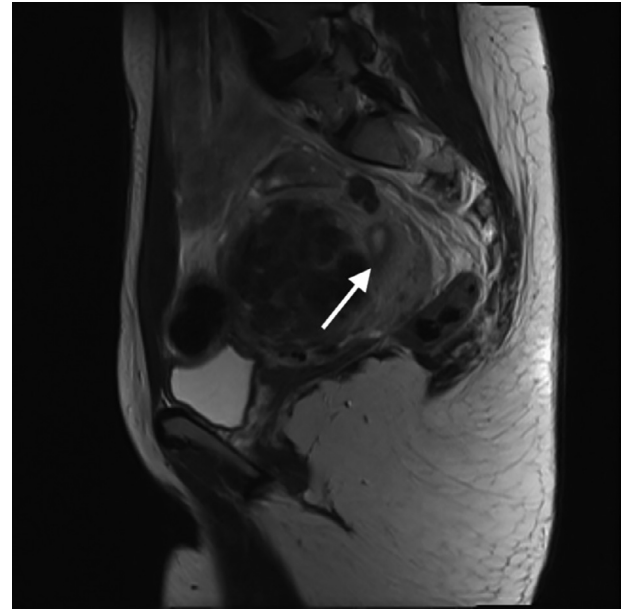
Pre-embolization state (2017) T2-weighted MRI sagittal view shows multiple myoma and pressure on endometrium (arrow).
